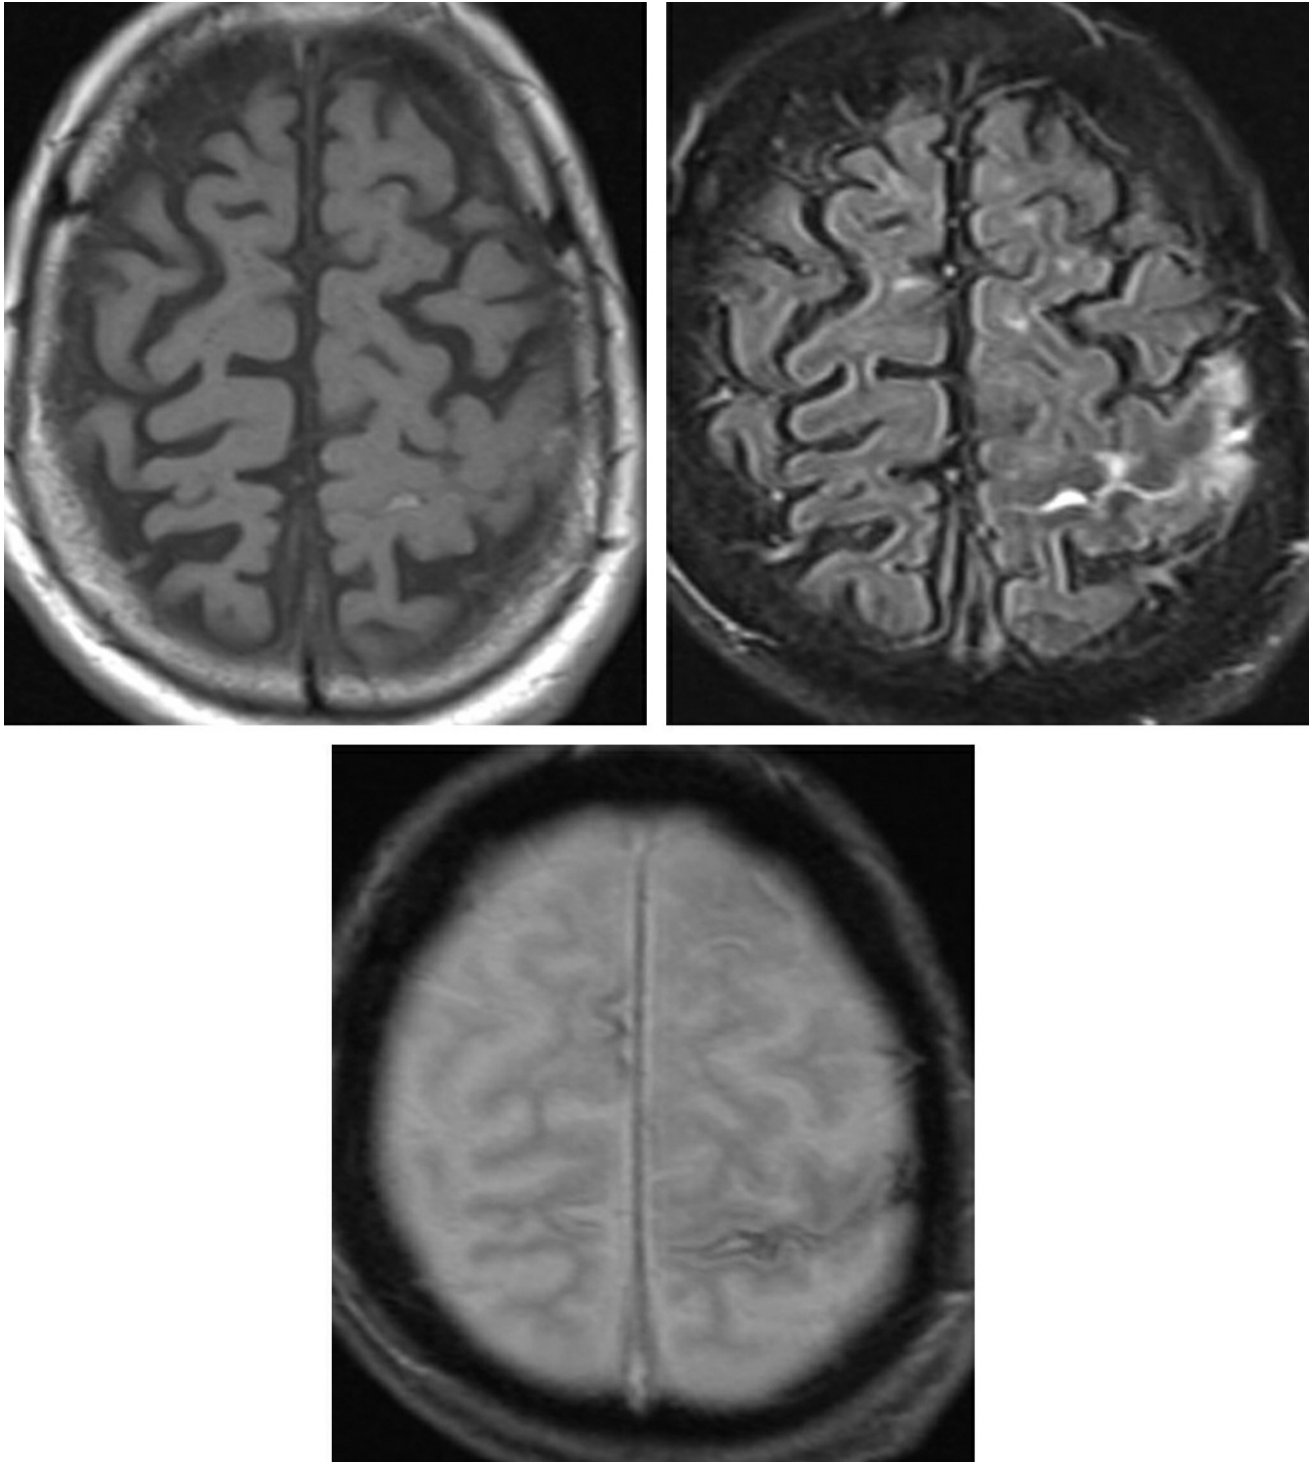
Early chronic subarachnoid hemorrhage is more difficult to see on this T1-weighted image as hyperintensity with a sulcus (top row left) but is much more conspicuous as
